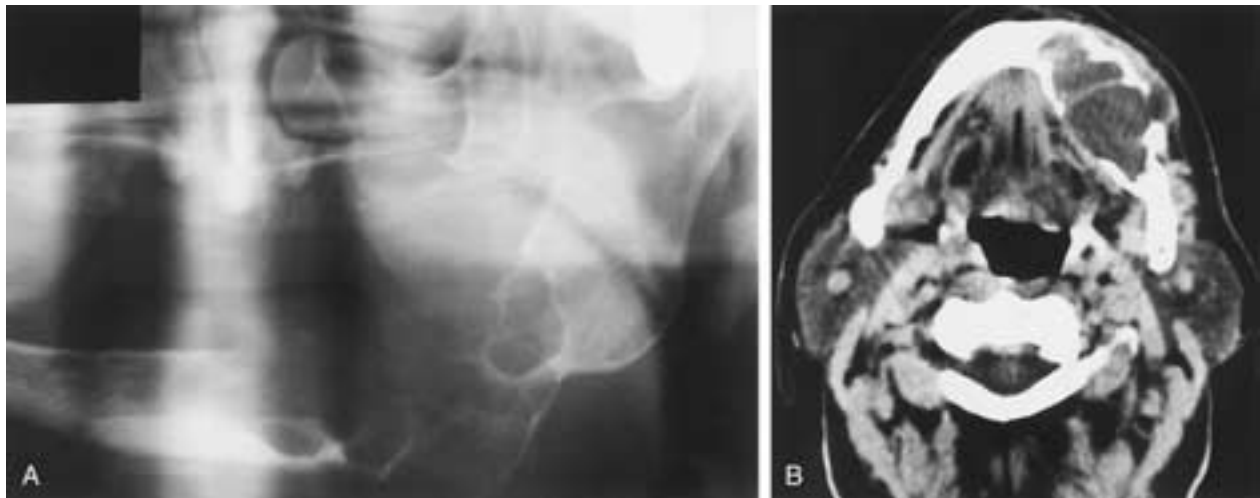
Ameloblastoma. A, Pantomogram of the mandible shows a multiloculated aggressive lesion in the body and ramus of the mandible with considerable loss of bone. B, Axial CT (soft-tissue window setting) shows the expansile lesion in the body and ramus. There is loss of bone medially and laterally. There is general low attenuation and slightly septated soft-tissue densities within the lesion. A small component of the tumor has penetrated through the lateral cortex into the adjacent soft tissues.
